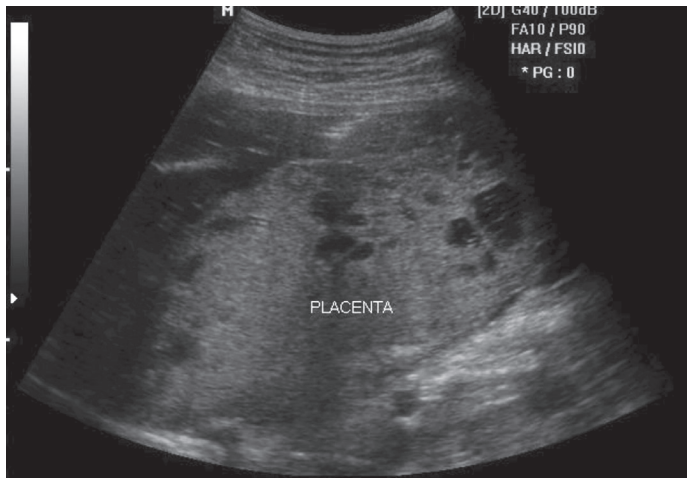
Ultrasound at 24 weeks and 1 day age of gestation: Molar changes in the placenta suggestive of complete hydatidiform mole.
